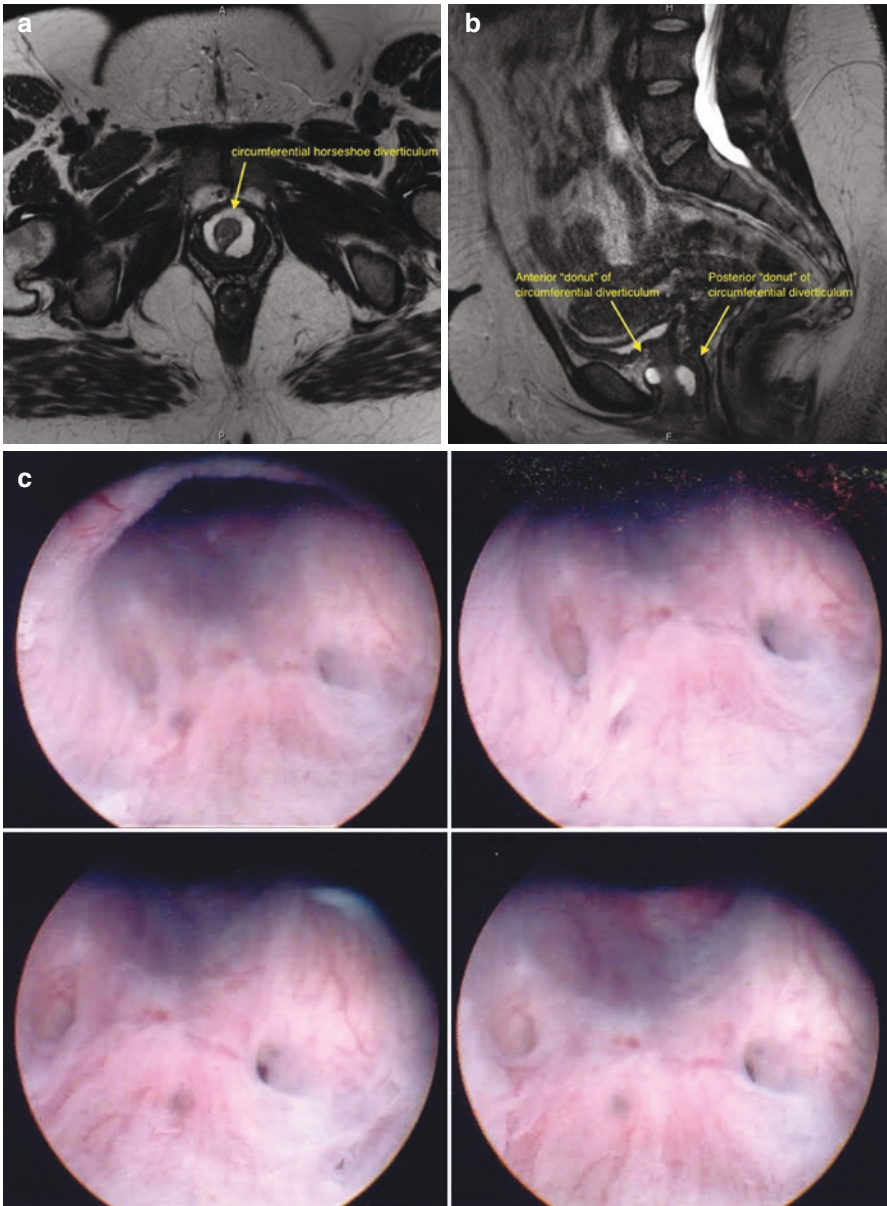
Urethral diverticulum. (a) MRI demonstrating circumferential diverticulum in female urethra. (b) Endoscopic view of urethra and orifice to urethral diverticulum. (c, d) Bulge at anterior vaginal wall from urethral diverticulum (Tic)
